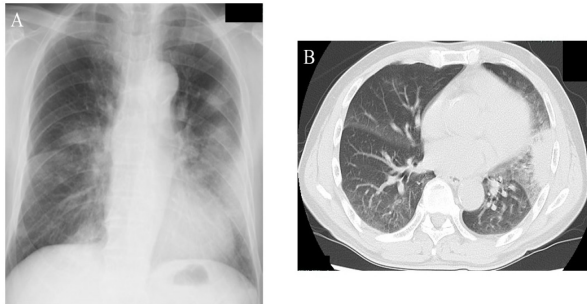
Imaging findings show bilateral multiple consolidations on admission (A: Xp, B: CT).
